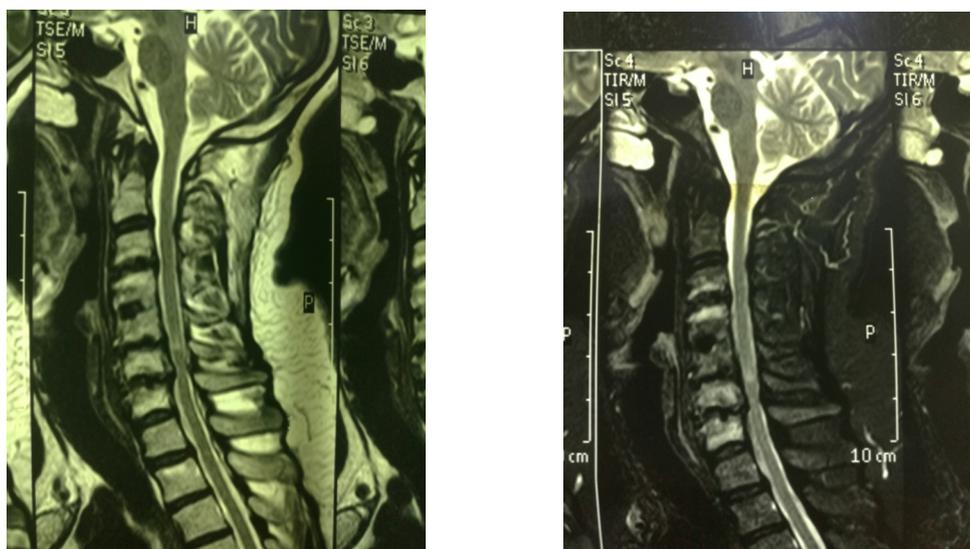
Post operative MRI T2 sagittal with 4 cervical cages.
